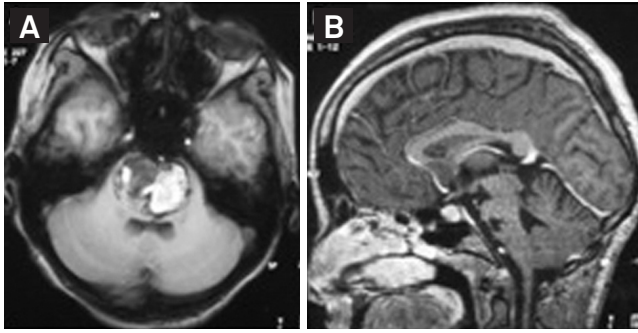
Pre (A) and postoperative (B) images of a brainstem cavernous malformation. This patient presented with tetraparesis and 11 points at the Glasgow Coma Scale. Three years after surgery she was asymptomatic. (A): axial T1-weighted magnetic resonance imaging revealed a typical cavernous malformation, characterized by heterogenic mass and hypointense halo signal around it; (B): sagittal T1-weighted gadolinium-enhanced magnetic resonance imaging revealed total removal of the cavernous angioma and decompression of brainstem (Patient 5).
